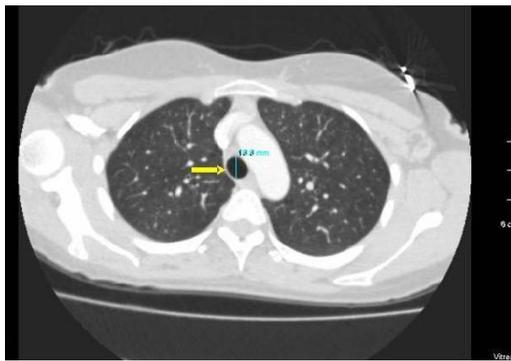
Trachea AP diameter measurement on axial CT image.
